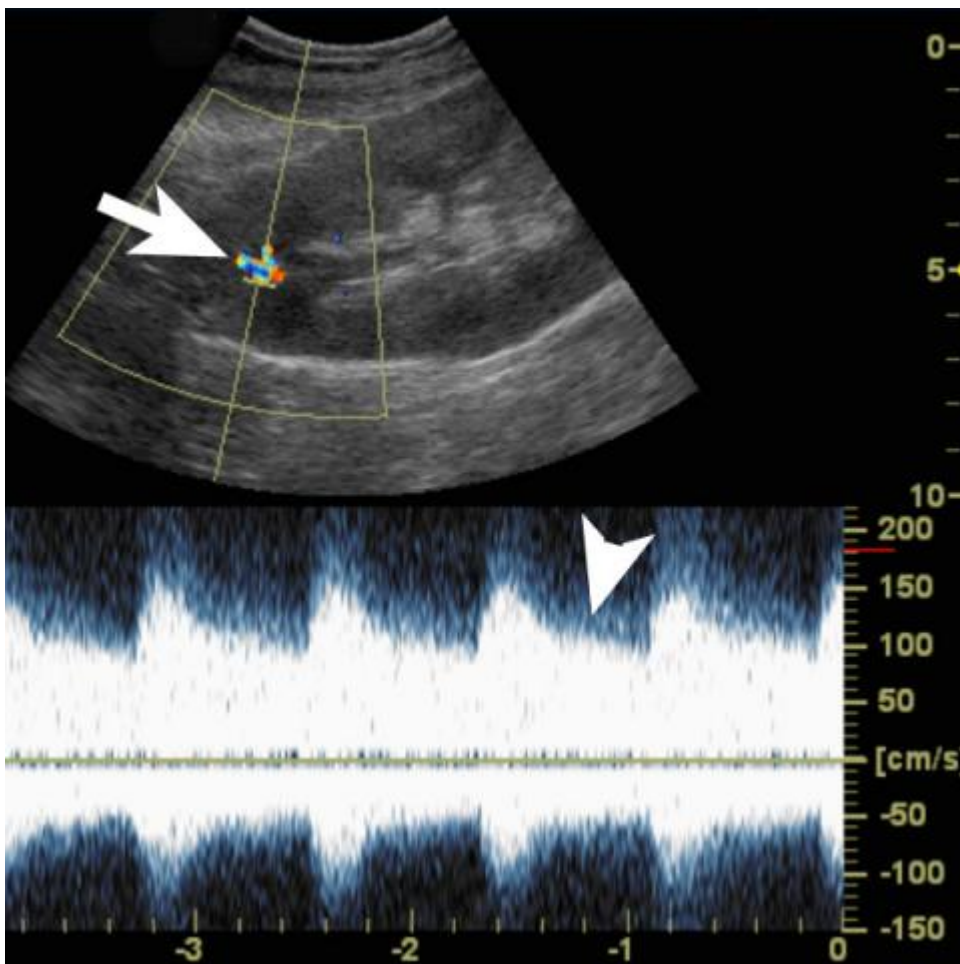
b Arteriovenous fistula. b) Follow-up spectral Doppler evaluation demonstrates focal color aliasing (arrow) at the superior pole biopsy site. There is a high velocity, low impedance waveform with increased diastolic flow (arrowhead) due to an arteriovenous fistula.
